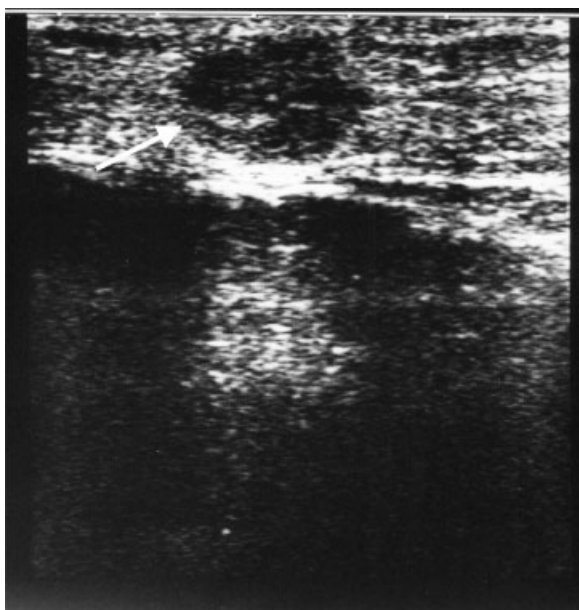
Sonogram of the palpable nodule at the puncture site of previous percutaneous ethanol injection shows a hypoechoic solid mass (arrow).
